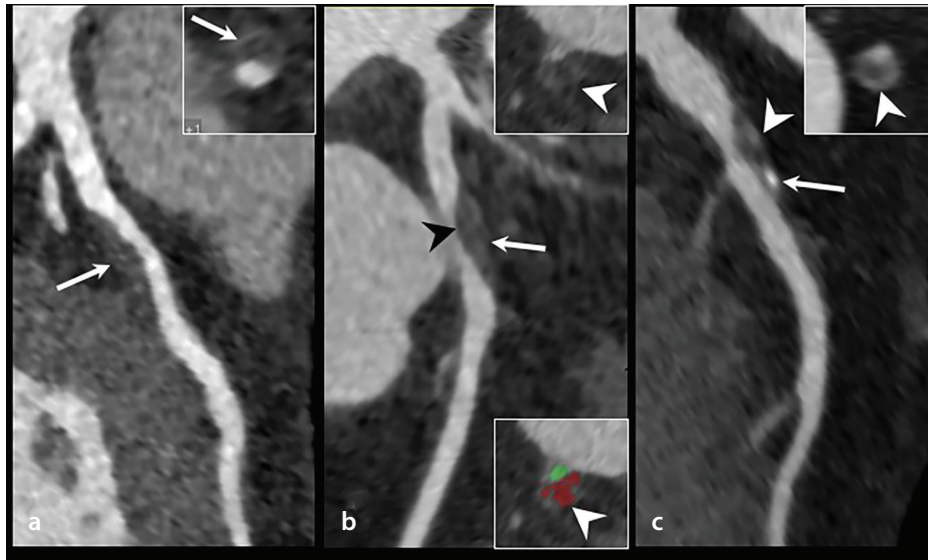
Analysis of vulnerable atherosclerotic plaques using coronary computed tomography angiography. High-risk (vulnerable) plaque features are classified as (a) positive remodeling (arrow); (b) positive remodeling with low-attenuation plaque (arrowhead); and (c) positive remodeling with spotty calcification (arrow) and low-attenuation plaque with a napkin-ring sign (non-calcified plaque with an enhancing ring, arrowhead).
